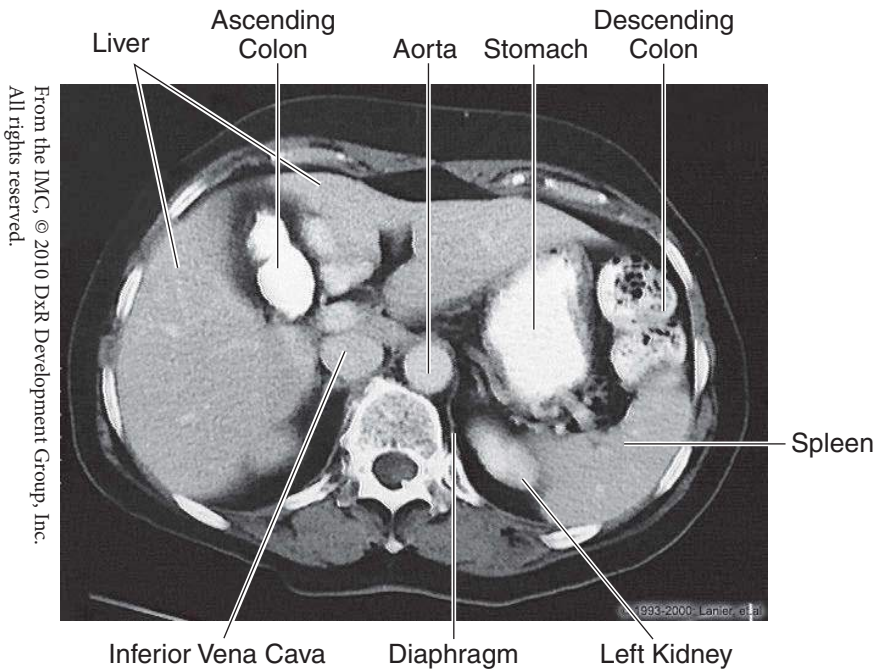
Abdomen: CT, T12
